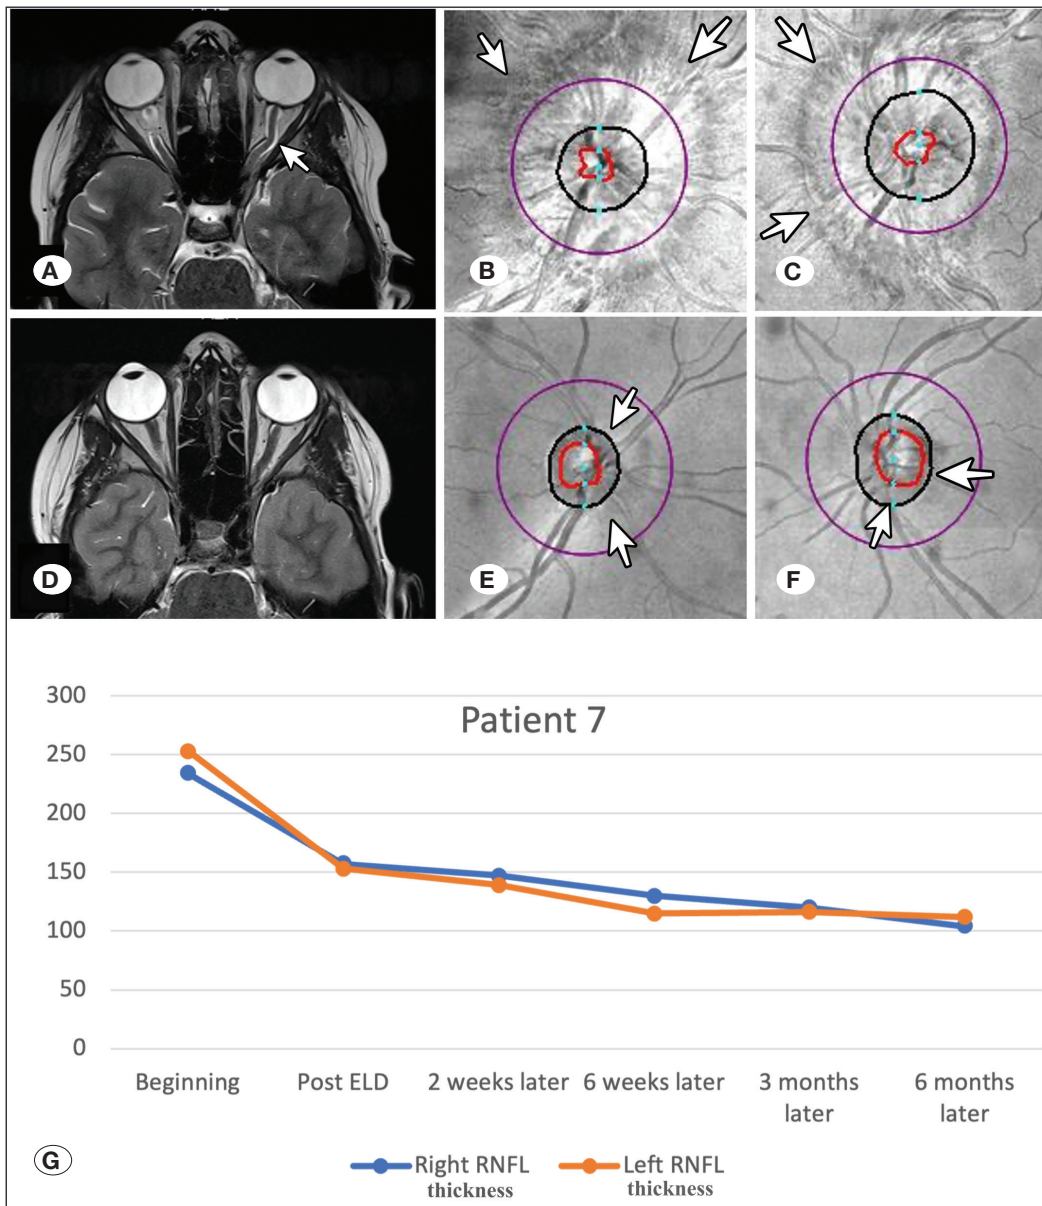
Images of representative Patient 7. A) T2-weighted axial MR image obtained before IIH treatment shows optic nerve sheath swelling with optic nerve kinking (arrow). OCT of the (B) right and (C) left eyes before IIH treatment show obvious swelling around the papillae (arrows). D) MRI obtained 6 months after IIH treatment (7 days of ELD + TPM, followed by TPM only) shows complete resolution of the optic nerve sheath swelling and optic nerve kinking. E, F) OCT obtained 6 months after the start of IIH treatment shows complete resolution of the swelling around the papilla. G) Graph showing the changes in OCT-RNFL thickness values within 6 months of treatment. There is a dramatic decrease in RNFL thickness at the end of the ELD treatment. The decrease in RNFL thickness continued during the follow-up period with oral treatment until physiological values were achieved. MR: Magnetic resonance, IIH: Idiopathic intracranial hypertension, OCT: Optical coherence tomography, MRI: Magnetic resonance imaging, ELD: External lumbar drainage, TPM: Topiramate, RNFL: Retinal nerve fiber layer thickness.
